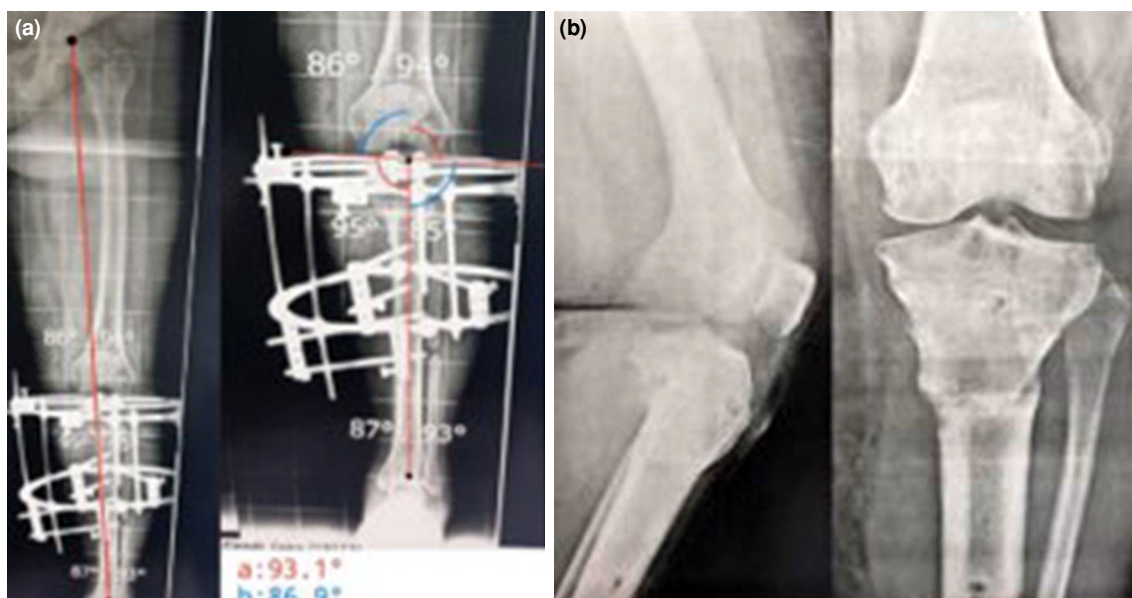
(a) Standing scanogram after correction of the limb alignment at four months for a 20-year-old patient. Angle (a): mMPTA=93 degrees. (b) X-rays after removal of the frame at five months for the same patient. mMPTA: Mechanical medial proximal tibial angle.
